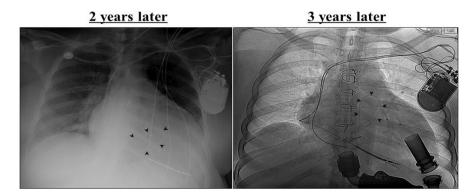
A chest radiograph (left panel) and fluoroscopic image (right panel) exhibiting a progressive prolapse of the left ventricular lead into the right ventricle and pulmonary artery, respectively
